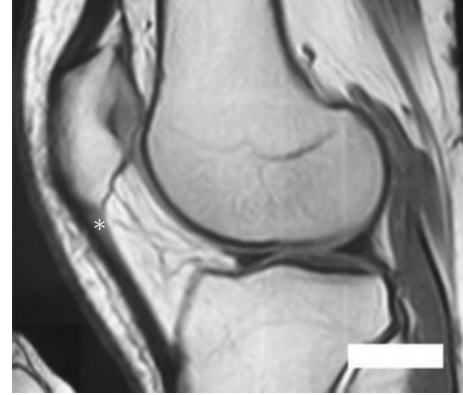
Preoperative magnetic resonance imaging showing hypodense area in the proximal aspect of the patellar tendon (*).
